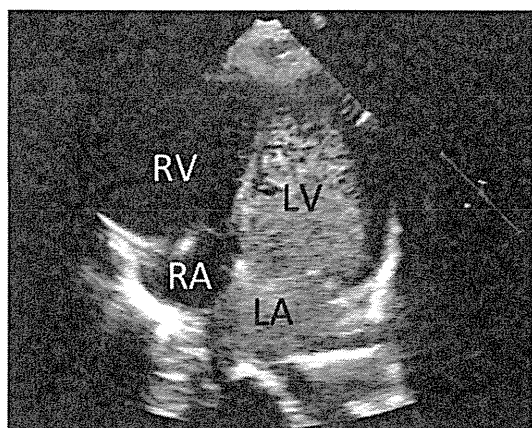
Transthoracic contrast echocardiography showing microbubbles from the pulmonary artery returning directly to the left atrium (LA). LV, left ventricle; RA, right atrium; RV, right ventricle.
